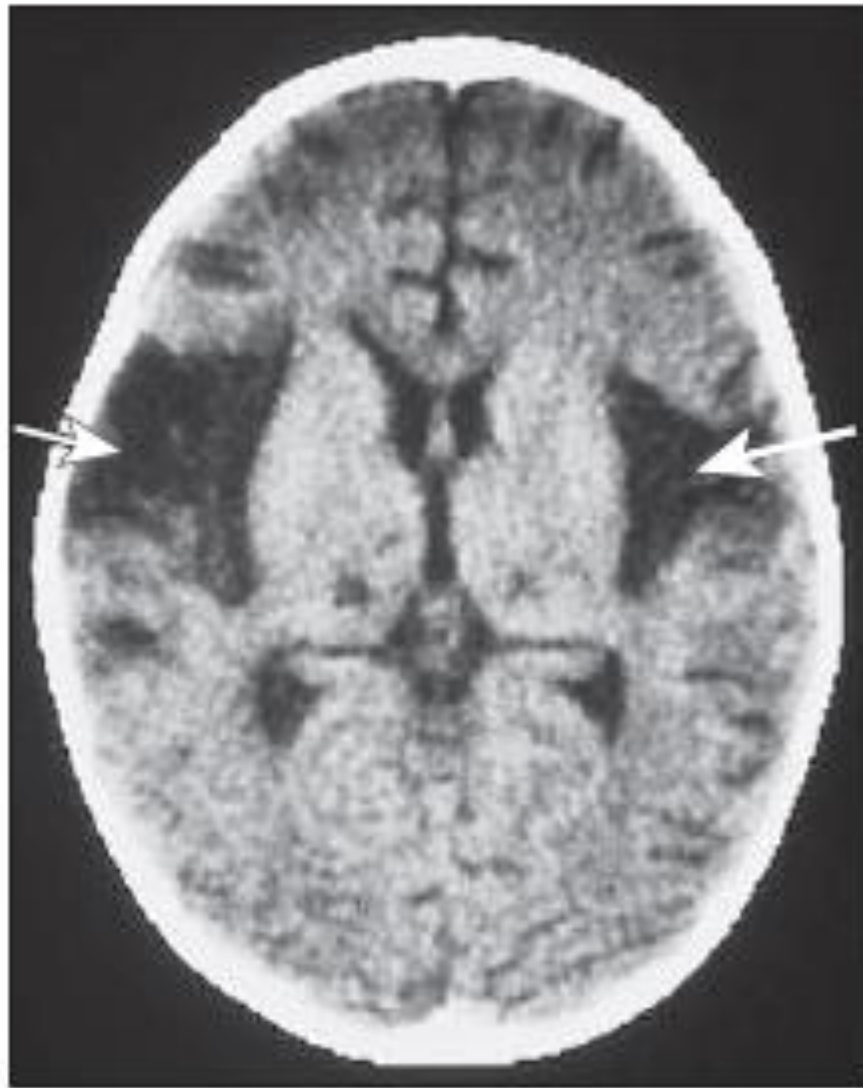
Herpes simplex encephalitis. The computed tomography scan shows gross atrophy from loss of neural tissue in the temporoparietal regions (arrows).
